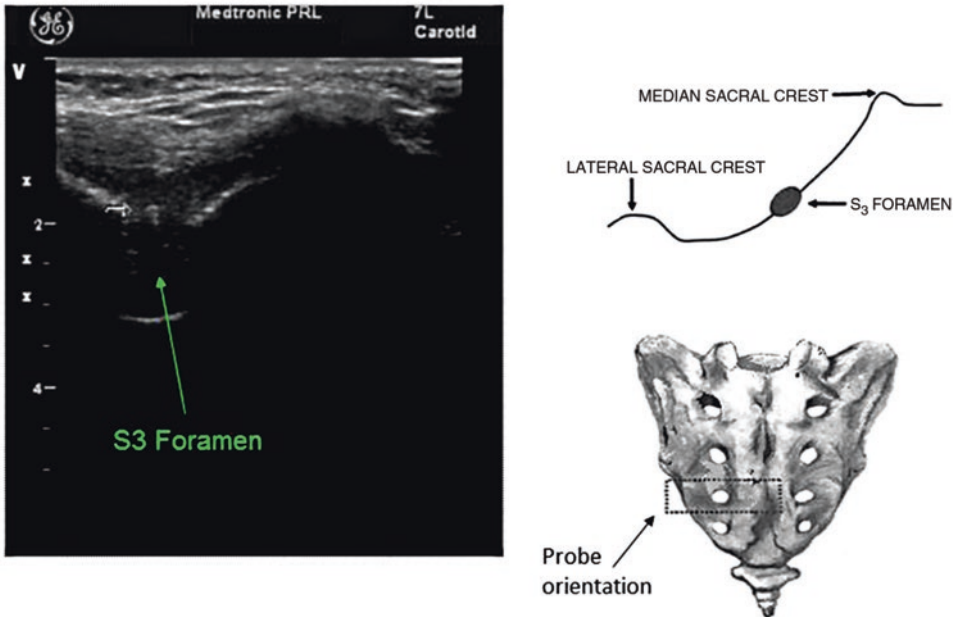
Ultrasound view of landmarks. In the axial view, the S3 foramen can be visualized between the lateral and median sacral crest. Reprinted with the permission of Medtronic, Inc. © 2017
